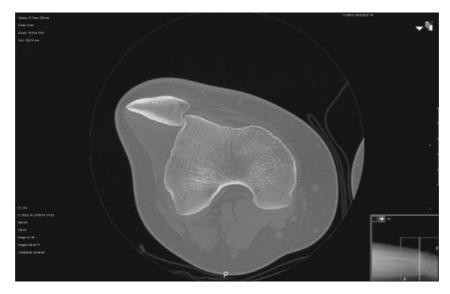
CT confirmation of the anatomical variant.
